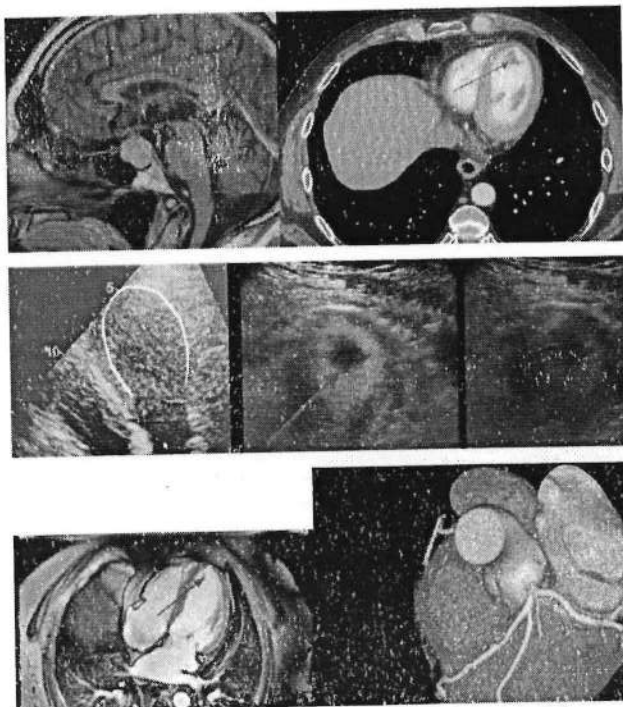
Compiled picture showing the pituitary MRI, ultrasound heart, CT thorax, Echocardiography of heart, cardiac MRI, and coronary CT angiography
